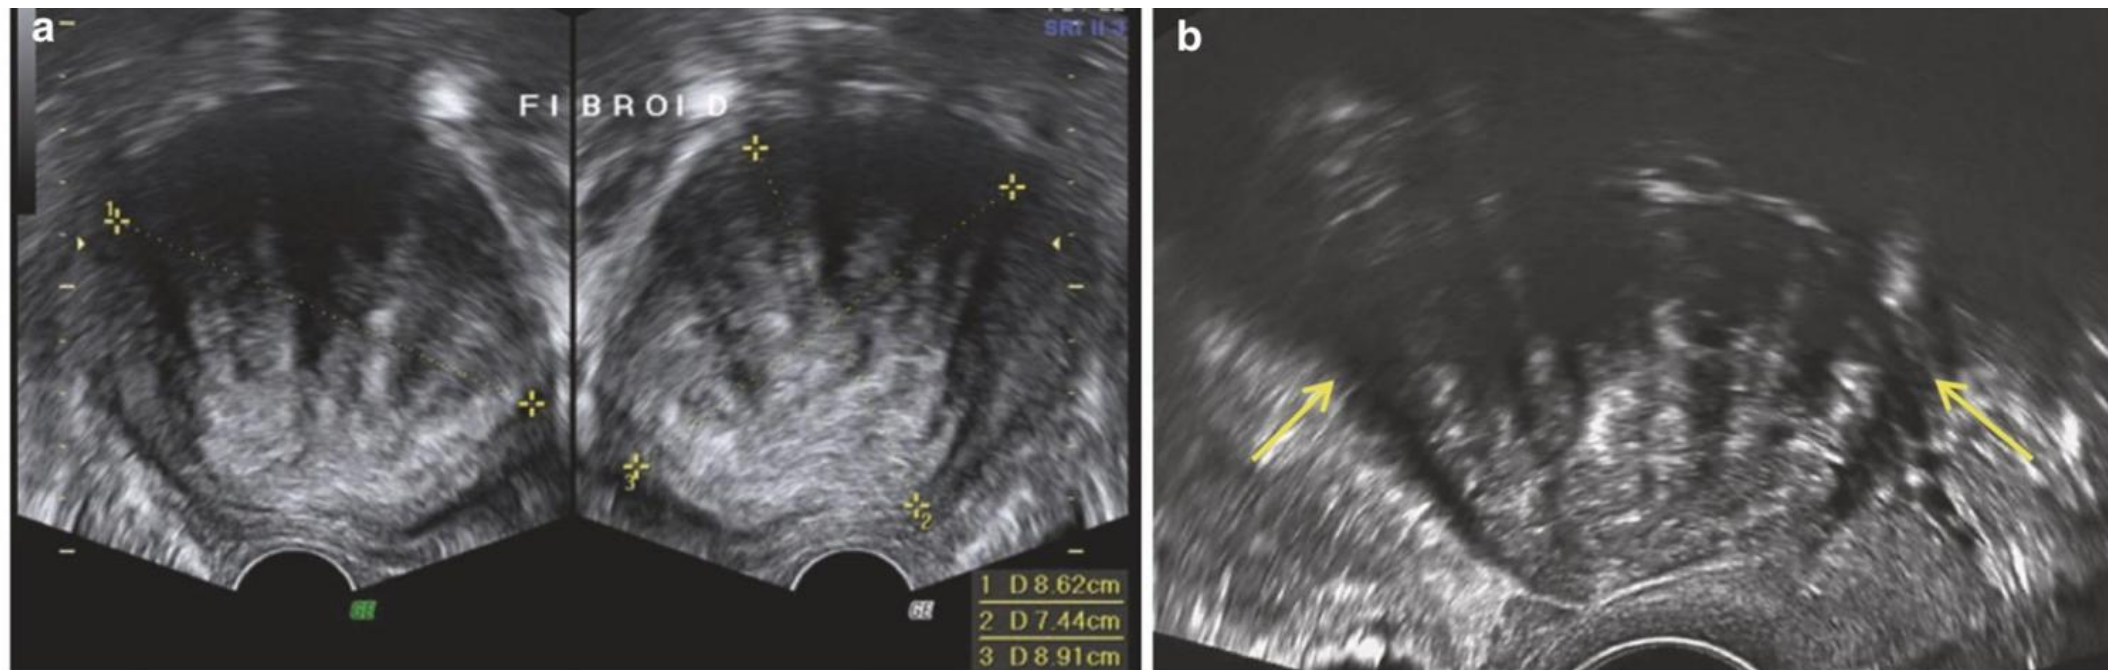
Typical fibroids (a, b) are seen on ultrasound as well-demarcated, solid masses with stripy, linear, fan-shaped, internal shadowing and shadowing from their edges (*arrows*)
